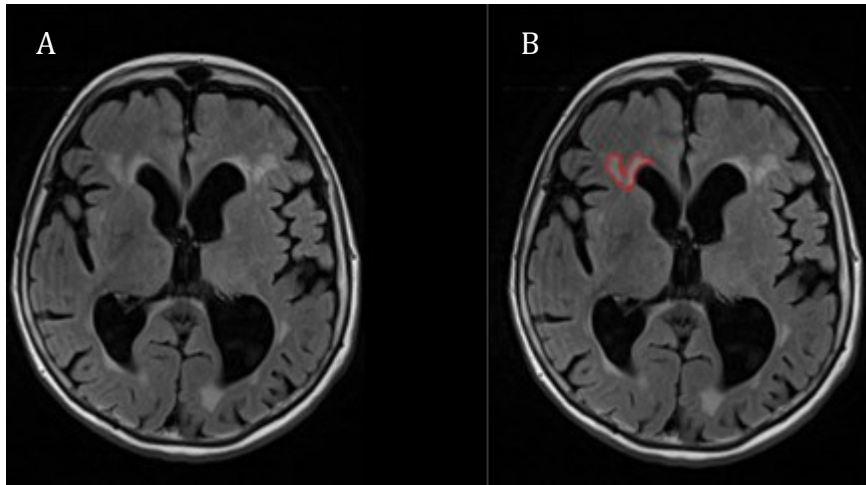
Example of lesion area segmentation. (A): Native FLAIR weighted scan with WMH. The red outline in (B) shows a segmented periventricular WMH. WMH=White Matter Hyperintensity; FLAIR=Fluid Attenuated Inversion Recovery
